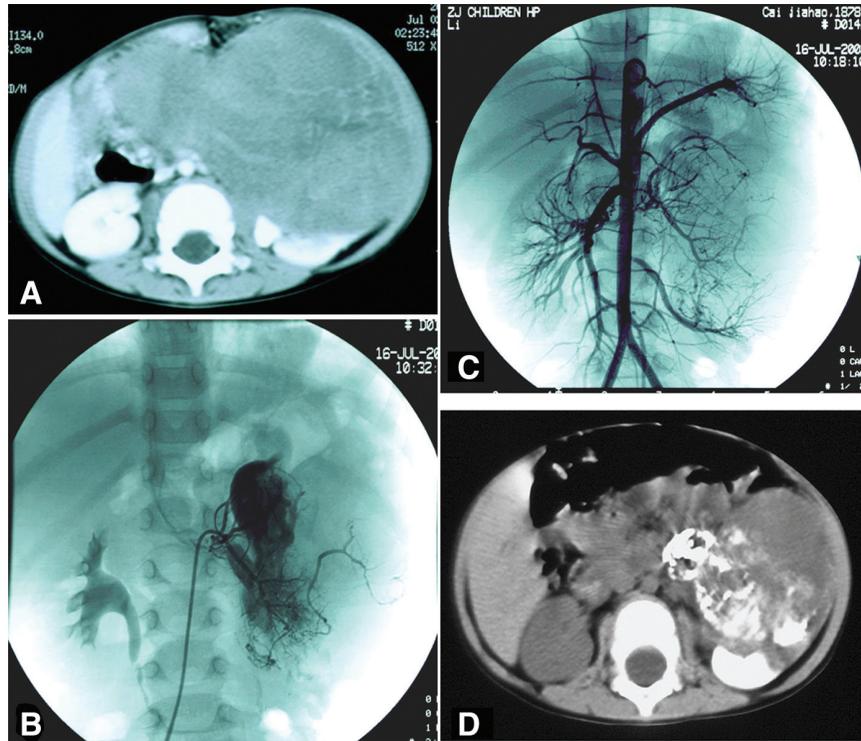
Preoperative TACE in a 2-year-old boy with left renal Wilms tumor. (A) Computed tomography (CT) finding left retroperitoneal huge tumor, invasion to the right side. (B) Aortography showing a large hypervascular lesion in the left kidney with abundant neovascularity. (C) Selective renal arterial catheterization and the chemoembolic emulsion infusing into the left renal artery. (D) Tumor volume is significantly reduced after alternating TACE and intravenous chemotherapy. Iodized oil deposits still visible within the tumor in the repeated CT scan before operation.
